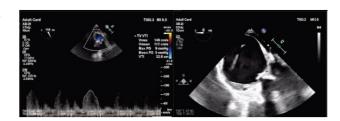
The modified bicaval view, continuous wave doppler showed a tricuspid valve gradient of 5 mmHg. Video 4. In the 0 midesophageal view, the interatrial septum is seen bulging into the LA, signifying pressure overload in the RA
